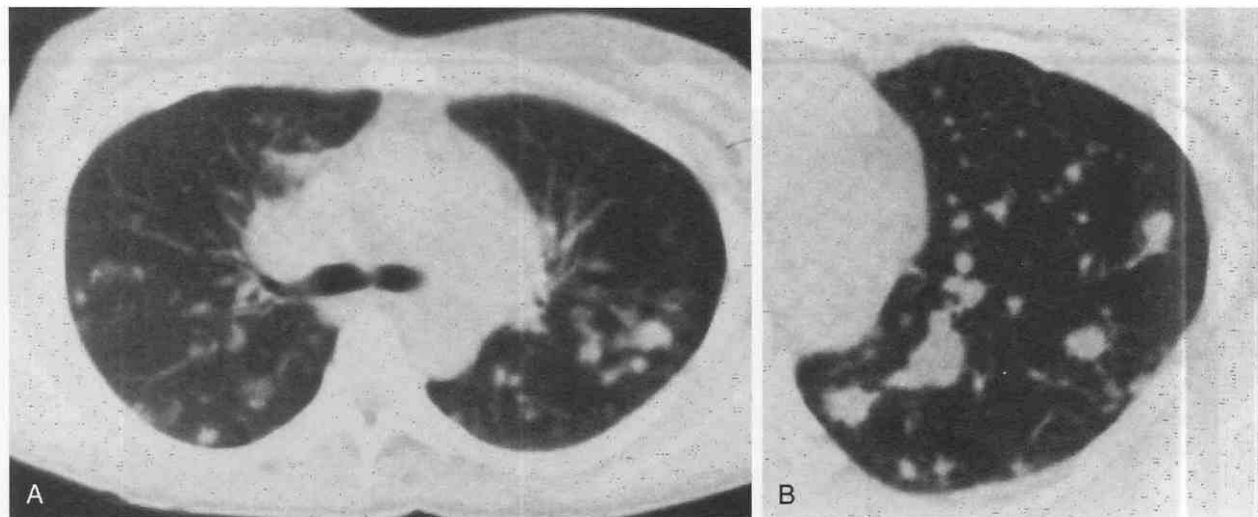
A and B, On these CT scans, areas of bronchogenic spread of tuberculosis appear as poorly margined, “fluffy” nodular densities of variable size.
